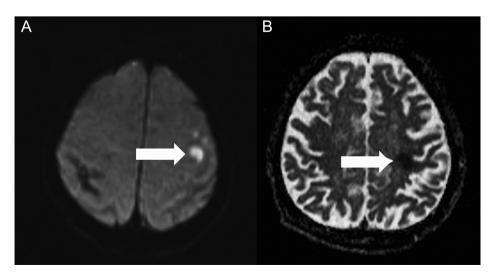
(A, B). Cerebral diffusion-weighted magnetic resonance imaging (DAMRG), A: Hyperintense area at diffusion-weighted sequence left frontal lobe precentral gyrus level, B: Hypointense area at ADC sequence left frontal lobe precentral gyrus level
